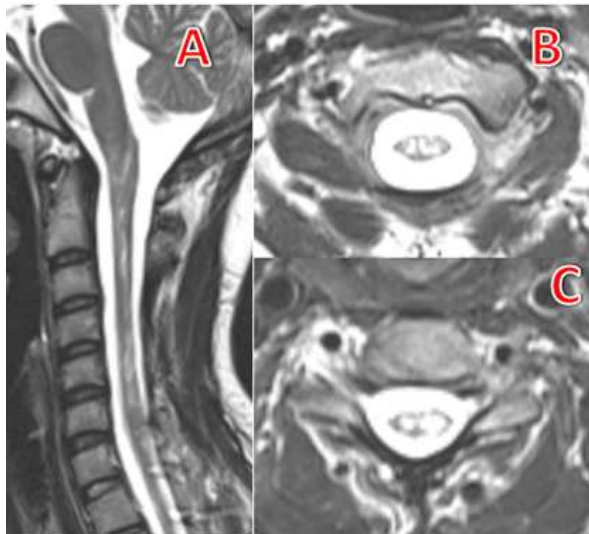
2 MRI of 21 year female diagnosed with NMOSD with second attack of LETM. A- sagittal section of T2WI showing LETM with cord atrophy, B, C- axial section of T2WI at different level showing central enhancement
